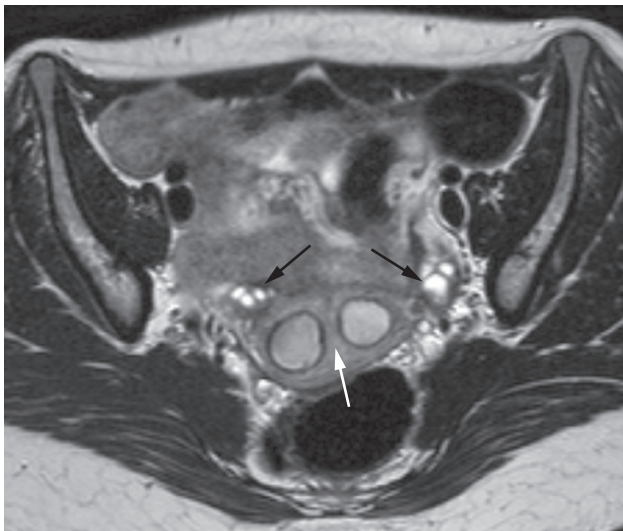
Axial MRI of a septate uterus, an anatomical variant. The endometrial cavity is divided into two compartments by a septum of myometrium (white arrow). Note the normal ovaries bilaterally (black arrows).
